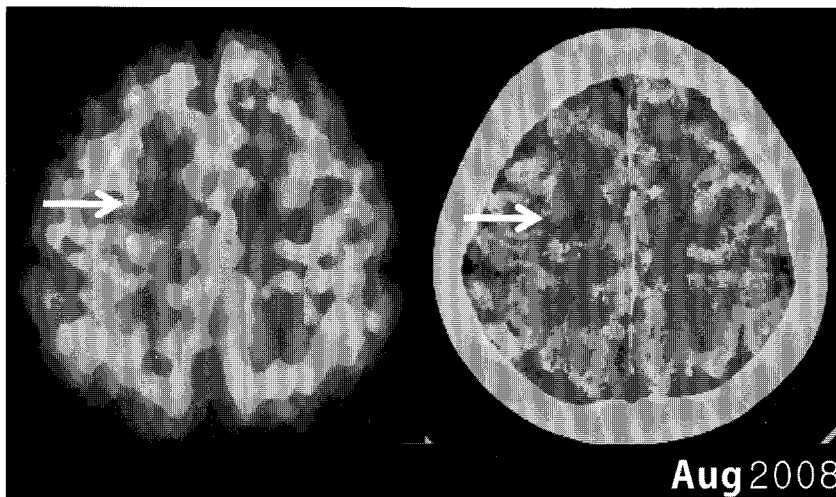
Follow-up FDG PET/CT was done after 6 months. Compared with the baseline scan, there was slight reduction (arrow) in the intensity of tracer uptake in right frontal lobe.
